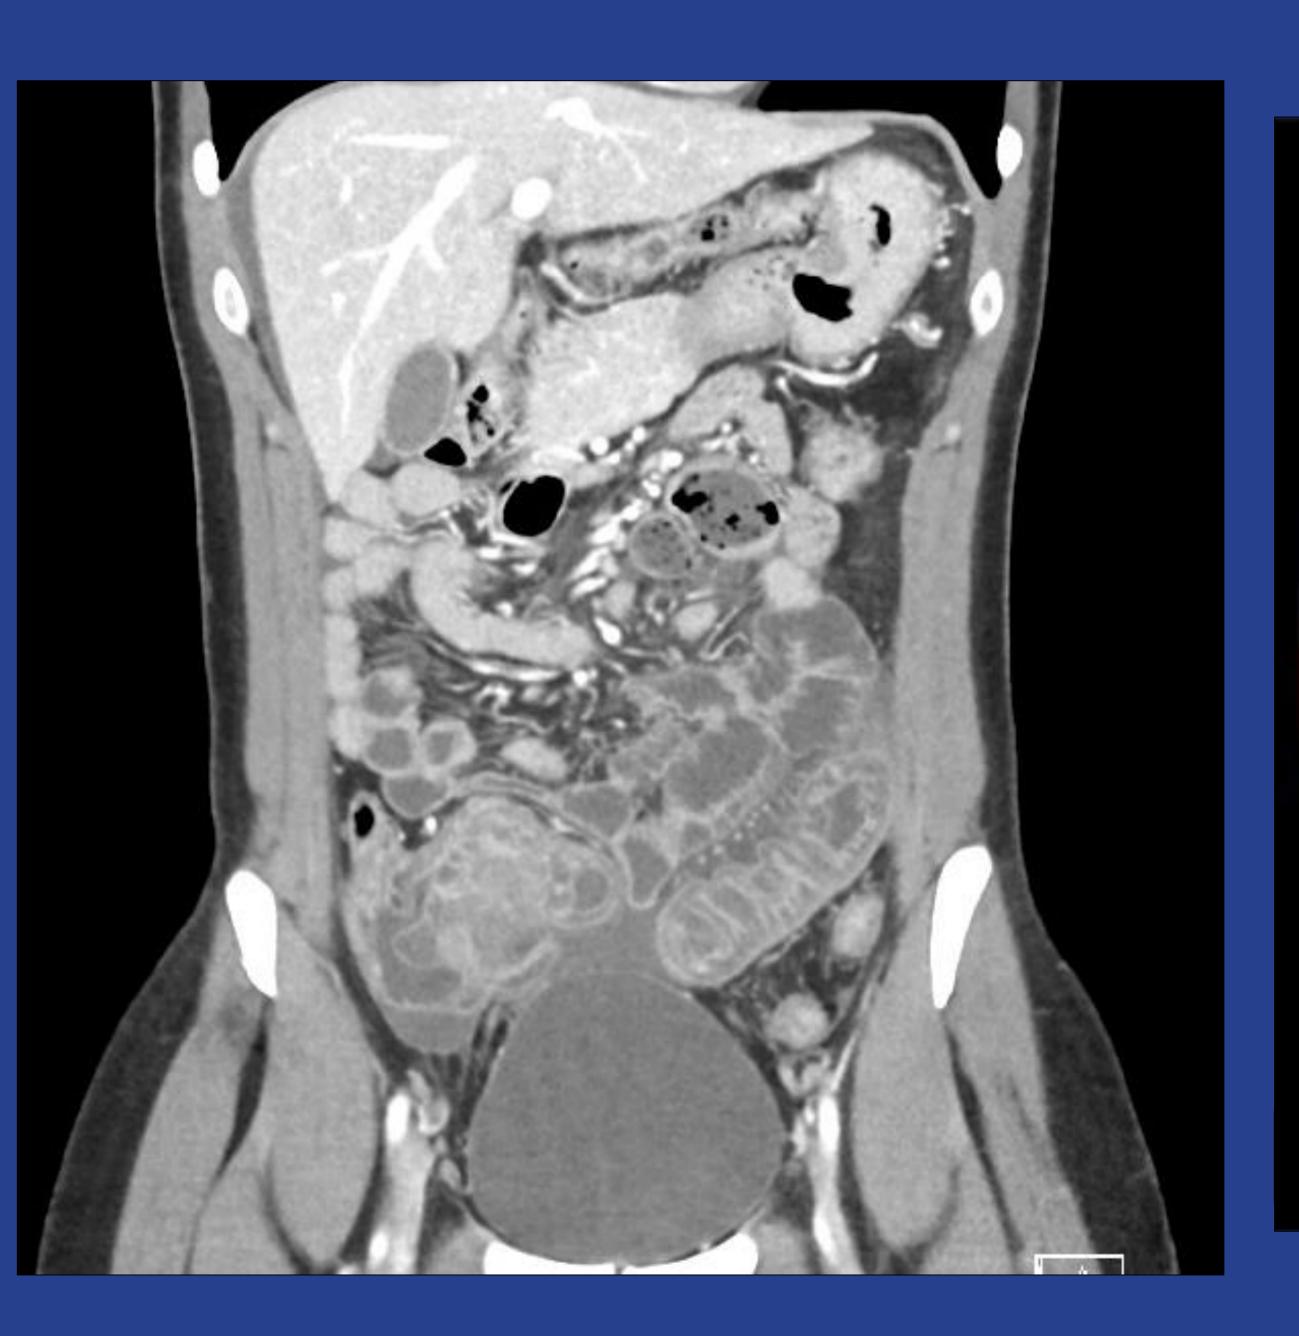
Computed tomography of abdomen and pelvis with contrast showing ileitis.
